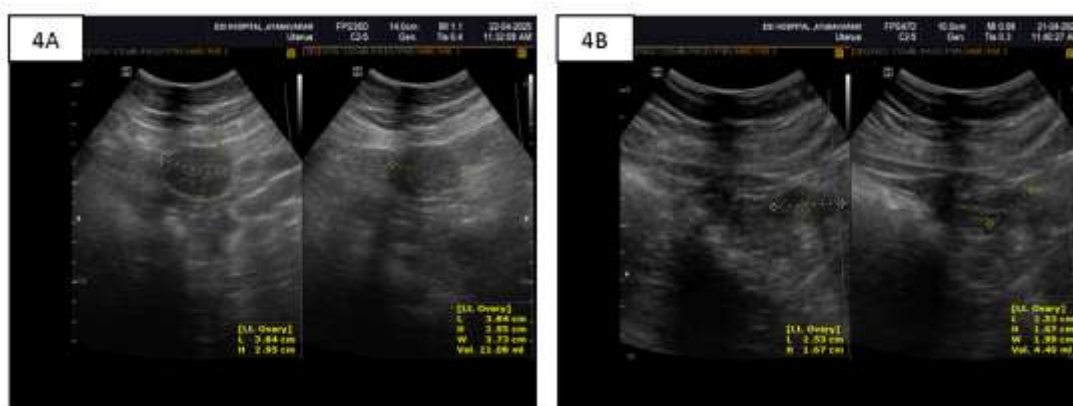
Left ovary ultrasound (Pre) Ayurvedha treatment.
